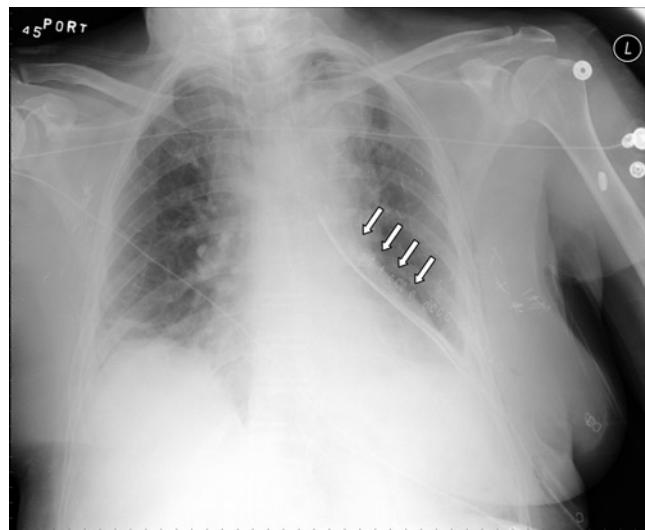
A chest X-ray of a female patient who had a left lower lobe lobectomy. The arrows are pointed to where the stapling line is. Also, there are bilateral infiltrates postlobectomy.
